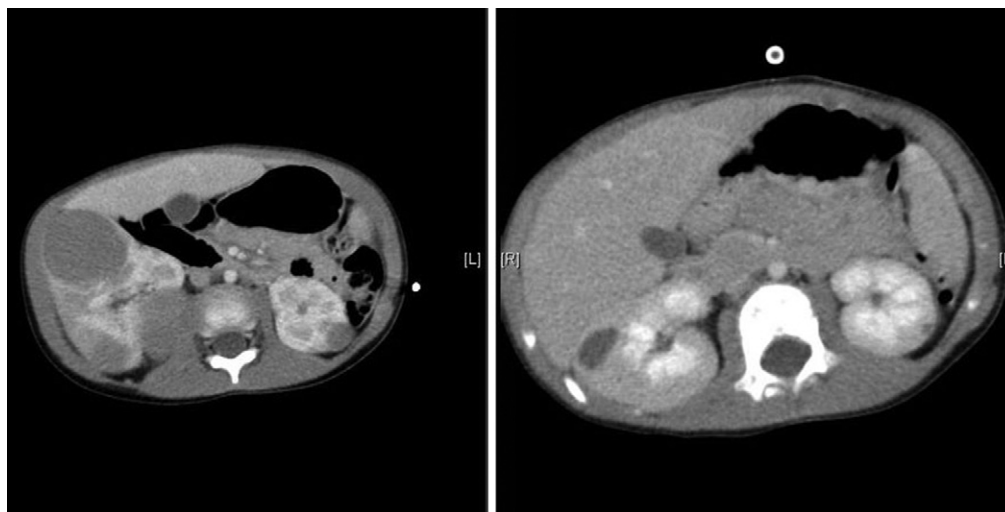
Two computed tomography (CT) scans of bilateral Wilms' tumor at presentation and after 6 weeks of chemotherapy.
